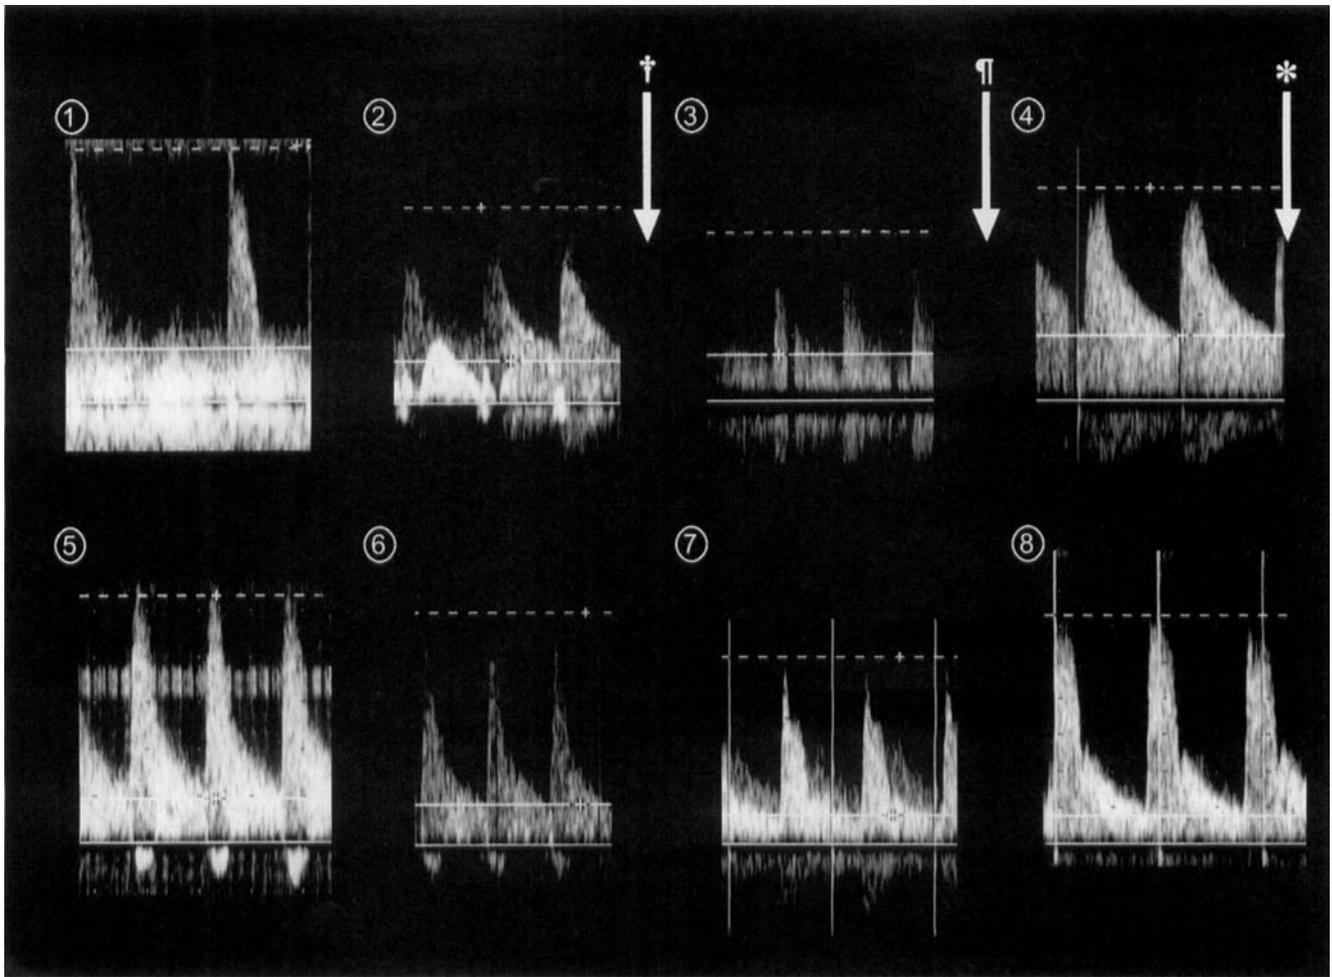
Serial changes in waveform of a graft artery (A3) with Doppler US. The serial number corresponds to those of the portal vein and hepatic vein
